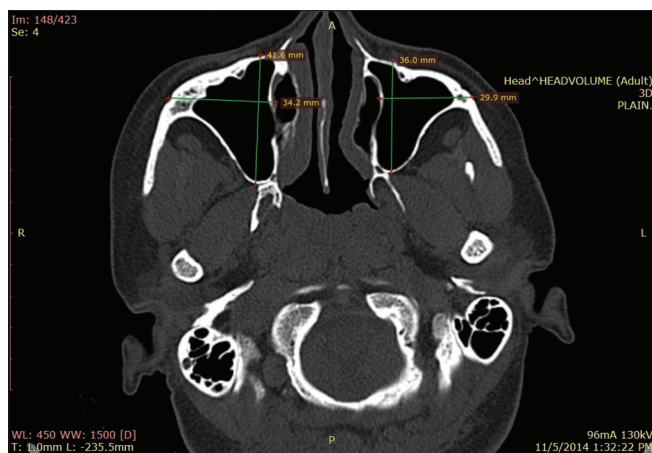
Axial computed tomography scan of head–bone window showing hypoplasia of left maxillary sinus
